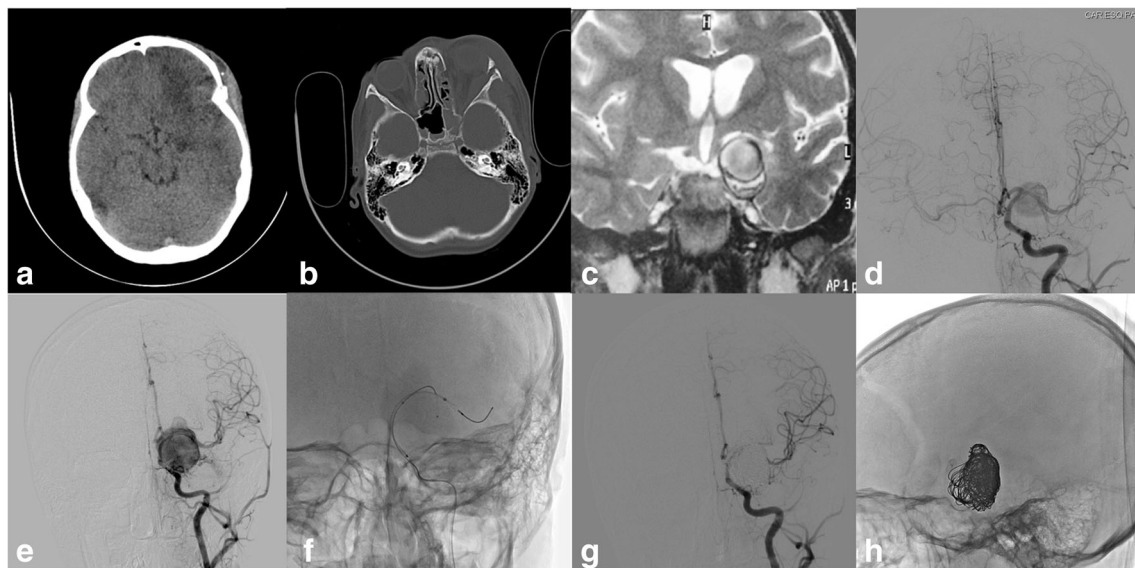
a, b CT scan 15 days after trauma demonstrates left frontal contusion and orbital fracture but no vascular anomaly. c MRI 30 days after trauma shows an aneurysm of the left supraclinoid internal carotid artery. d Angiogram demonstrates a 17-mm aneurysm of the communicating segment of the left internal carotid artery. e Angiogram
